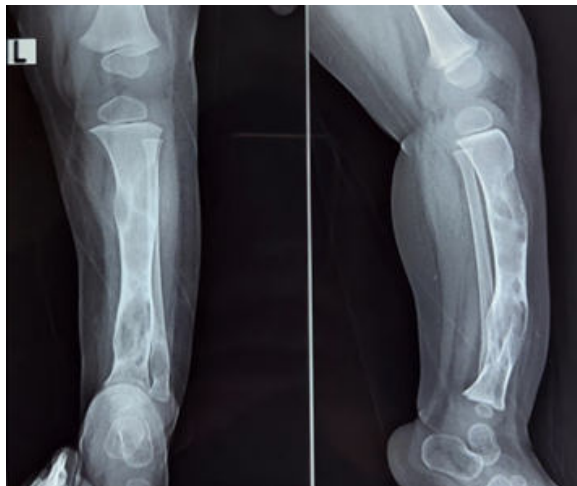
Anteroposterior and lateral view of plain X-ray showing a large osteolytic lesion in tibial shaft with cortical expansion and anterior bowing on lateral radiograph.
